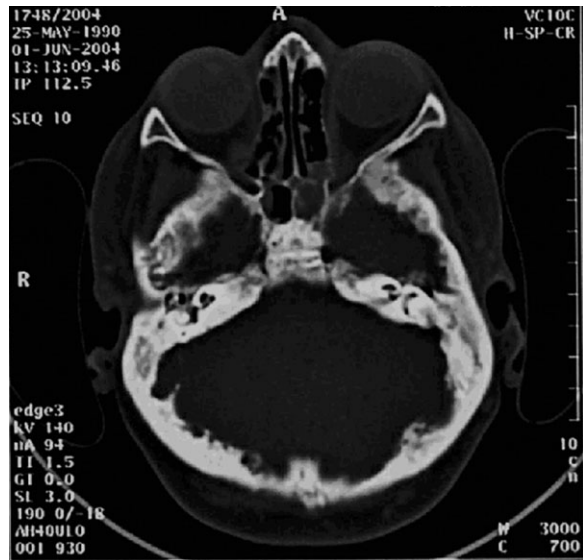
CT examination – the skull base and petrosal sclerosis.
